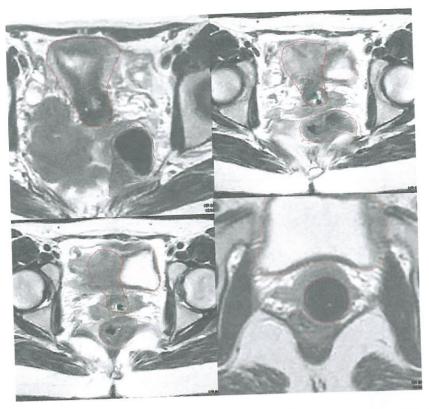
T2 weighted MR images in axial plane from different levels, with the patient and the applicator device in treatment position. The applicator geometry is accurately visualized as well as the surrounding tissue and the cervical cancer extension.
